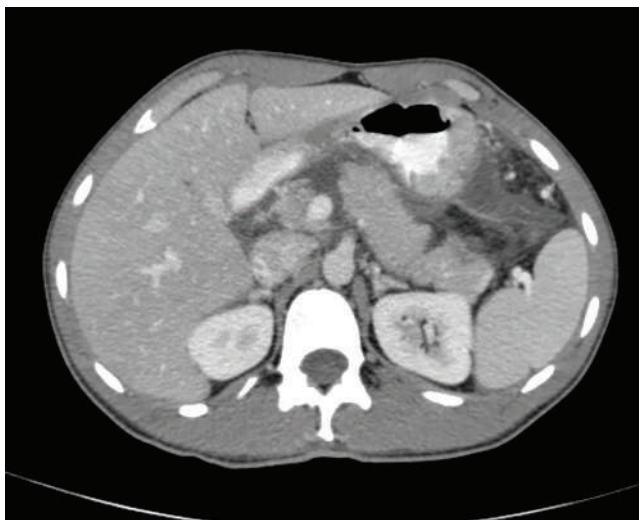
CT imaging shows distal pancreatic injury.
